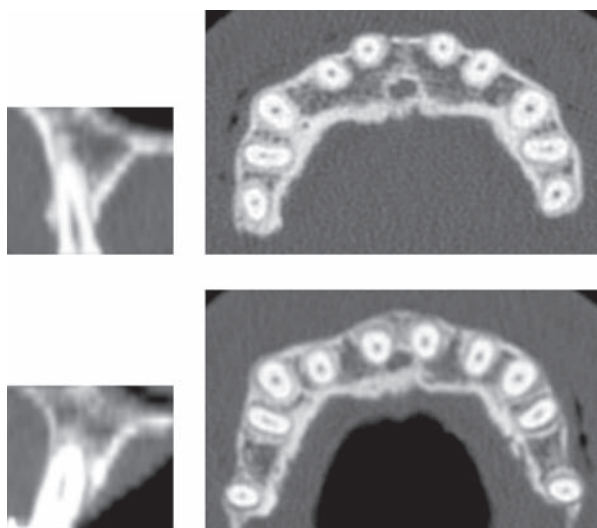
Axial and frontal (region 15) CT scans from baseline and at the start of retention, subject 4.
